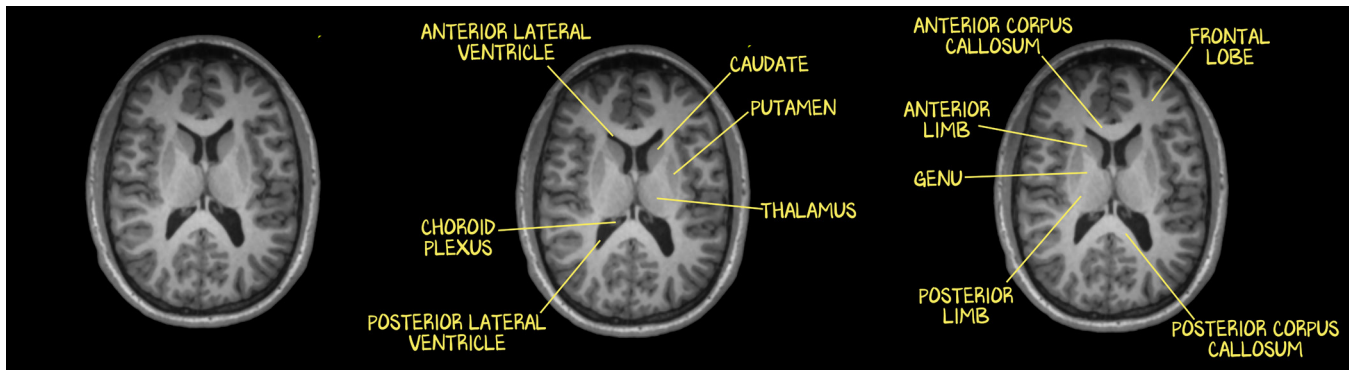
The Radiographic Ganglia
